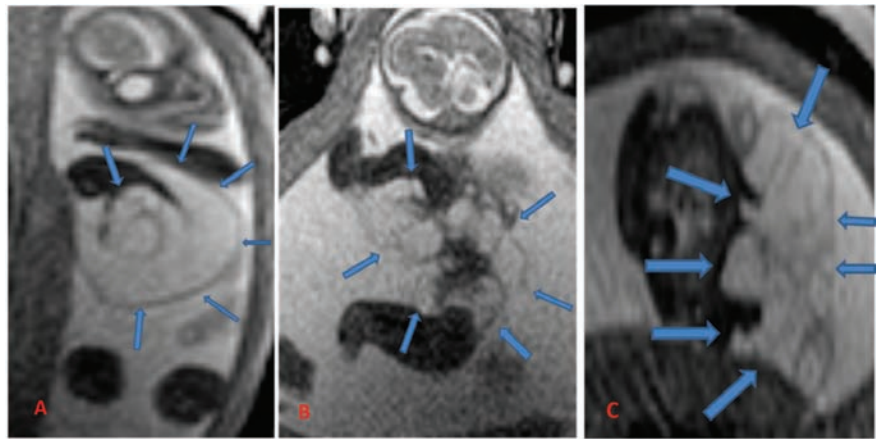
Antenatal T2 weighted MR images of multiculer giant hiperintens cystic higroma (arrow) which arise from right arm, axilla, pectoral region and right thorax. (A) A coronal oblique section which includes bilateral upper extremity and low extremity, (B) a parasagittal cross section at the level of right arm and leg, (C) an axial image at the level of axilla.
